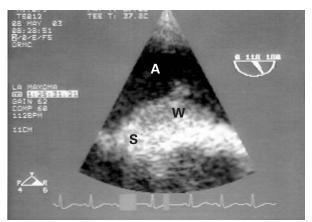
Transesophageal echocardiography of the heart shows the irregular atrial wall.
